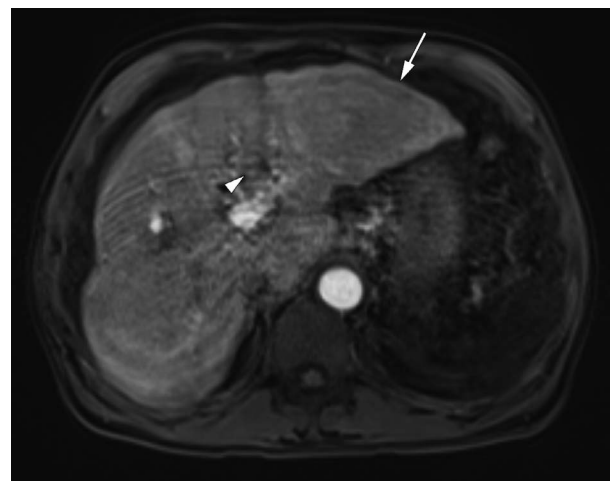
I-HCC. Annotated. Liver. MRI. T1 weighted. Fat suppression. Contrast enhancement. Arterial phase. Axial plane. An arrow points to an I-HCC. An arrowhead points to tumor thrombus in the left portal vein.
